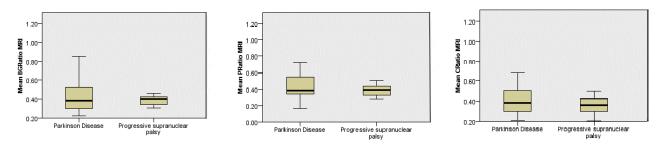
The distribution of basal ganglia, putamen and caudate uptake ratios between Parkinson's Disease and Progressive Supranuclear Palsy in co-registered MRI/SPECT images.
